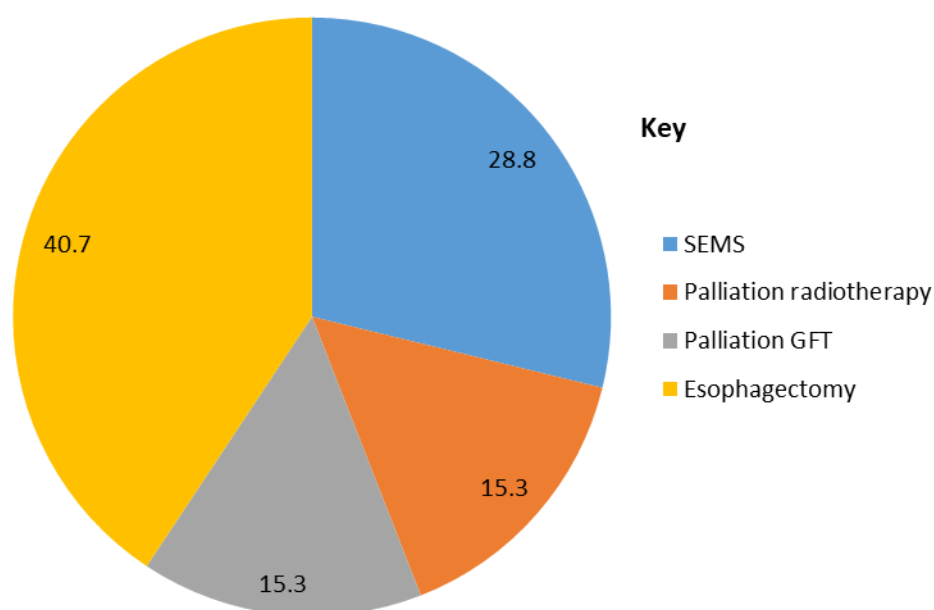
Shows 40.7% esophagectomy rate among patients who had thoracic CT scan at MNH in 2018
